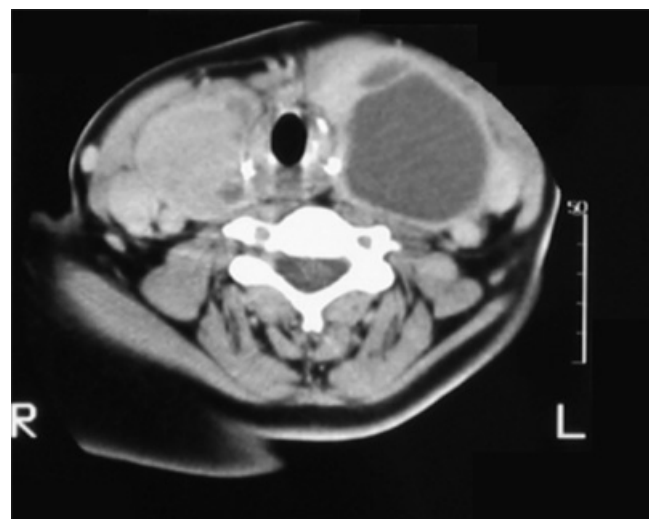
A 77-year-old female with thyroid papillary cell carcinoma with type IV and VI CT manifestations.
